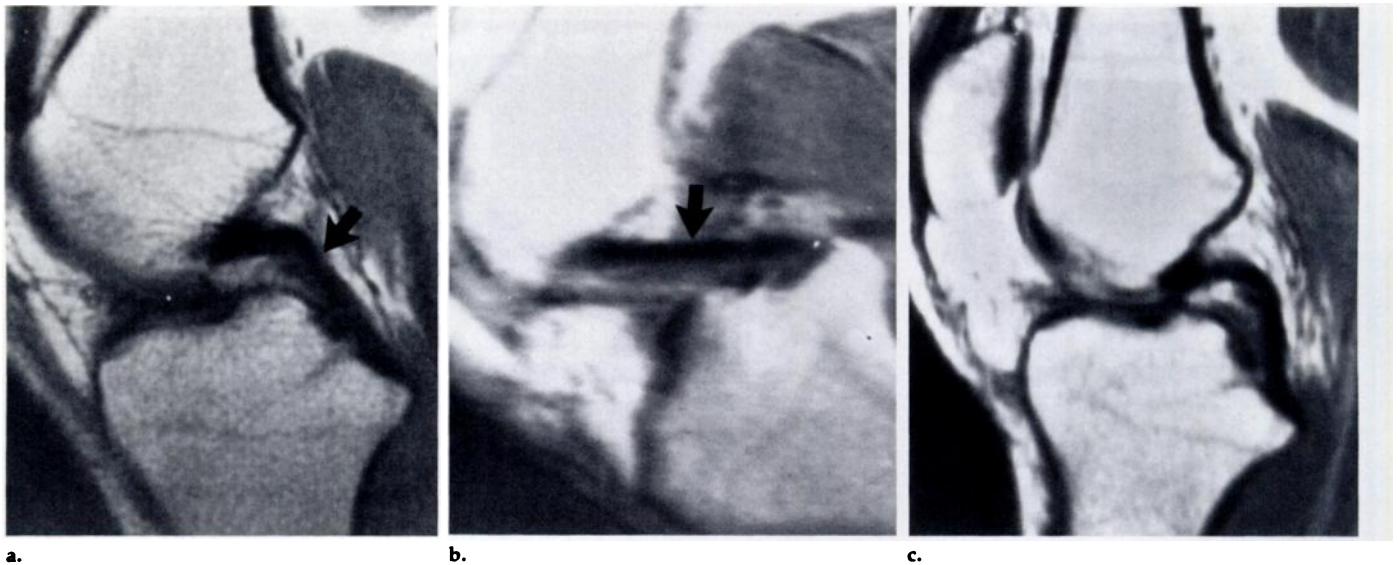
Sagittal T1-weighted images of PCL of a normal 23-year-old volunteer. (a) Knee relaxed in 10° of flexion and 15° of external rotation, as for routine imaging. The PCL (arrow) is arcuate and has uniform low signal intensity. (b) In 90° of flexion the PCL (arrow) is taut. (c) In 5° of hyperextension the PCL shows laxity. Note redundancy of the patellar ligament.
